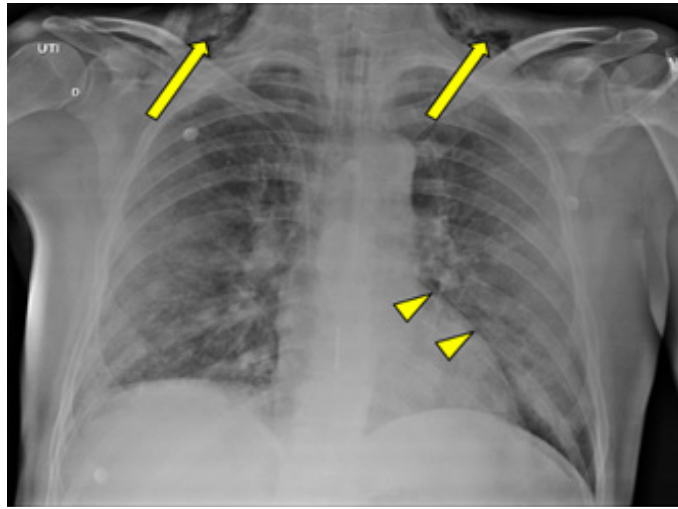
Chest X-ray performed on day 4 of hospitalization, after admission on ICU. The image showed bilateral infiltrative opacities, cervical subcutaneous emphysema (arrows) and signs of pneumomediastinum (arrowheads).
